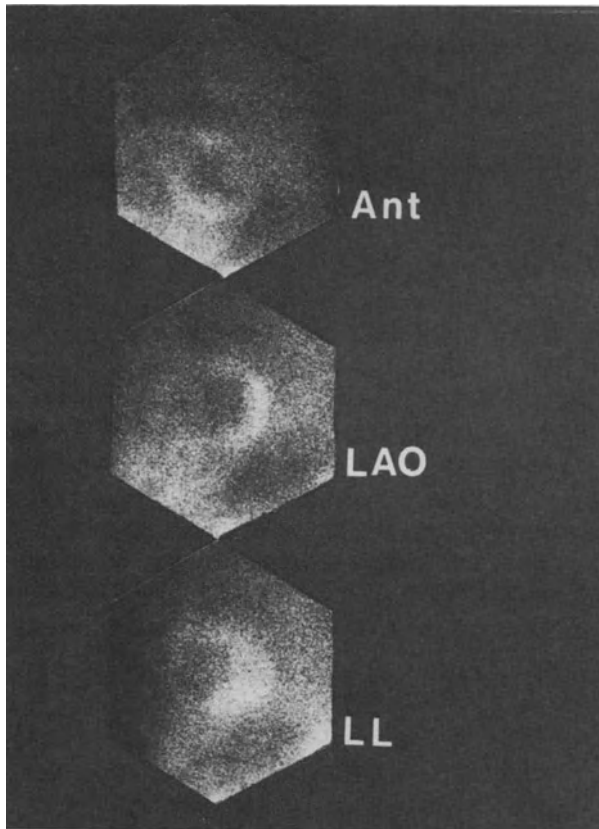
Resting thallium-201 scintigram of a patient with an acute anteroseptal myocardial infarction. There is a defect in the anterior wall seen in the anterior (Ant) and left lateral (LL) views, and a defect in the septum seen in the left anterior oblique (LAO) view.
